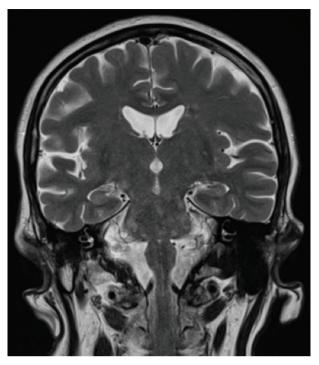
Magnetic resonance imaging, T2 sequence: coronary section, hyperintense punctiform lesions.
